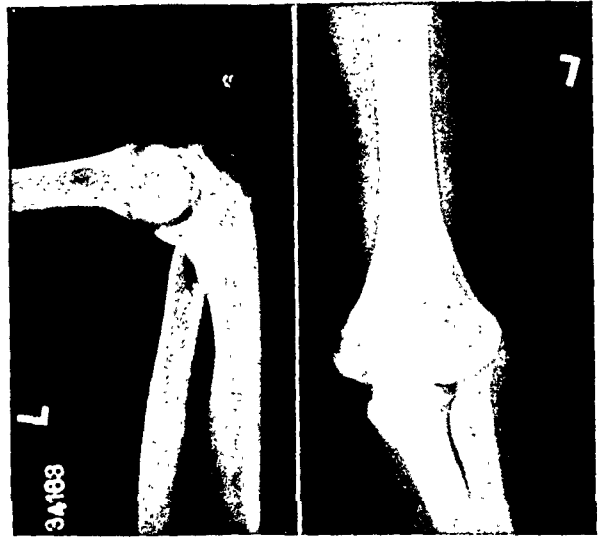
Roentgenograms of the left elbow showing the deformity of the proximal end of the radius and the dysplasia of the proximal radio-ulnar articulation.
